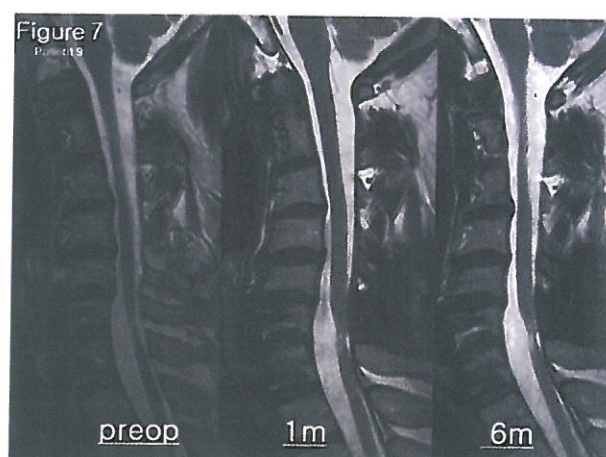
In Patient 9, thickening of spinal cord at proximal and distal portion to injured site was shown in T2 weighted image of the follow-up MRI.
